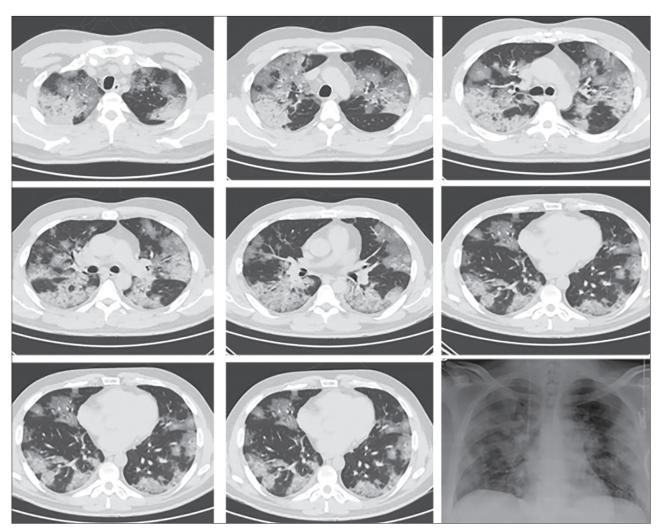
Computer tomography results at emergency unit and chest X-ray at ICU admission
